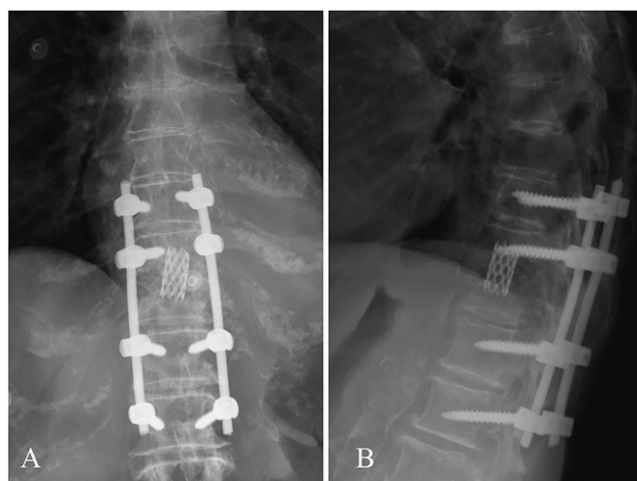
Postoperative radiographs showing T9–L1 instrumented fusion and T10–11 mesh cell.
